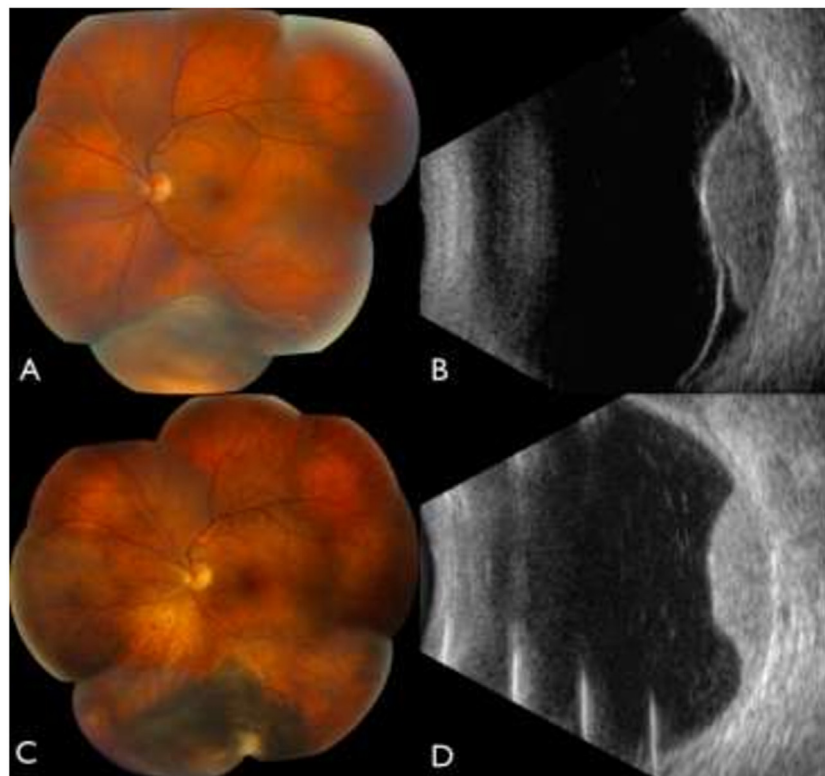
Choroidal melanoma treated with plaque radiotherapy. A 60-year-old female presented with (A) choroidal melanoma located inferiorly measuring $18 \times 14 \times 5.5$ mm with associated exudative retinal detachment and (B) acoustic hollowness on B-scan ultrasonography. (C) At 4-months follow-up after plaque radiotherapy, the subretinal fluid had resolved with tumour regression down to (D) a thickness of 4.3 mm.
